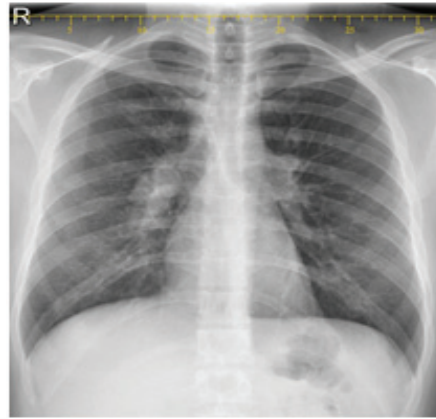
Chest X-ray PA view showing bilateral hilar lymphadenopathy
